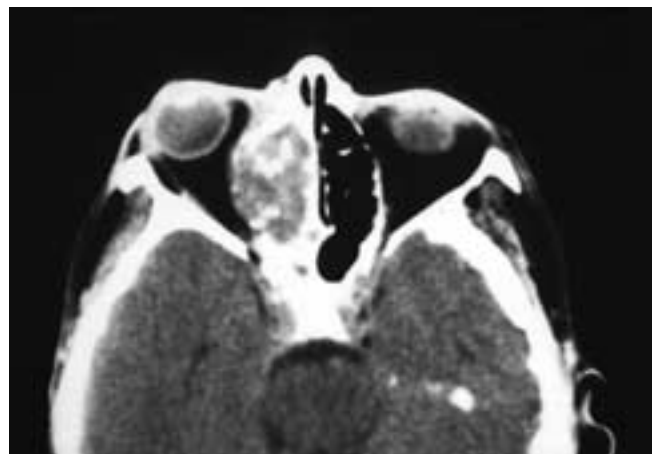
Axial CT scan shows an expansile mass in the right ethmoid complex that is bulging into the right orbit. Most of the lamina papyracea and ethmoid septations are destroyed or thinned. Radiodensities within the mass were residual pieces of bone. This patient had a melanoma.
